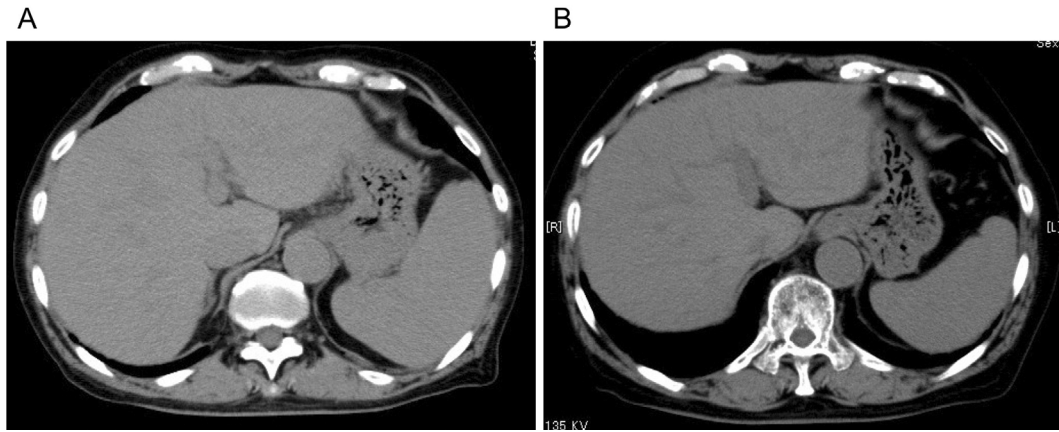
Computed tomography (CT). CT at diagnosis (A) and at 8 months after the initiation of treatment with ruxolitinib (B).
